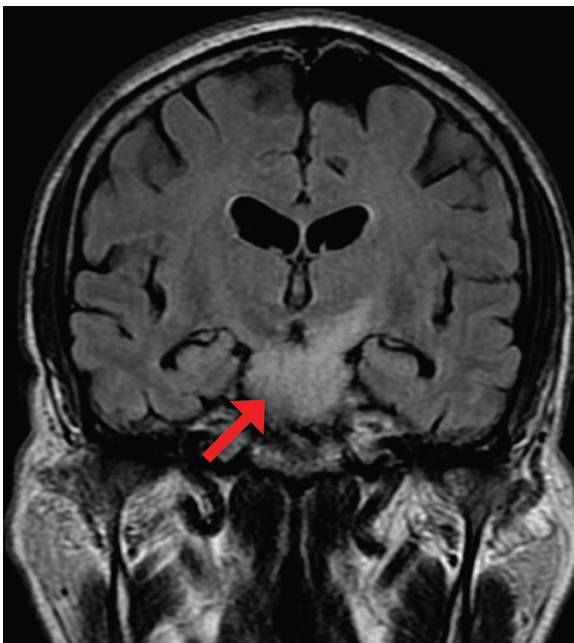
Coronal FLAIR T2 image shows brainstem encephalitis in a patient presenting with headache and fever.
